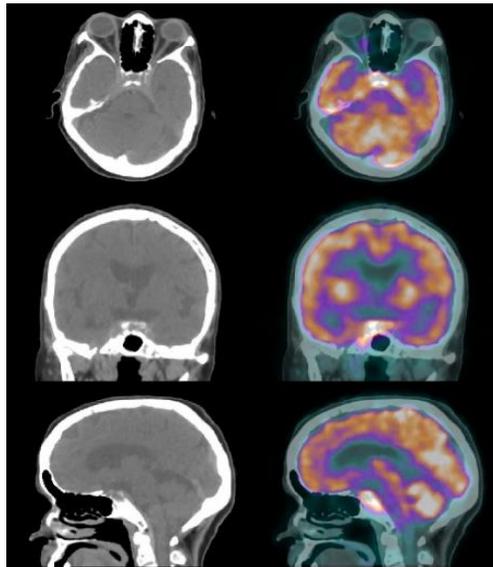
PET CT (Feb 2020) s/o isolated pituitary metastatic lesion
